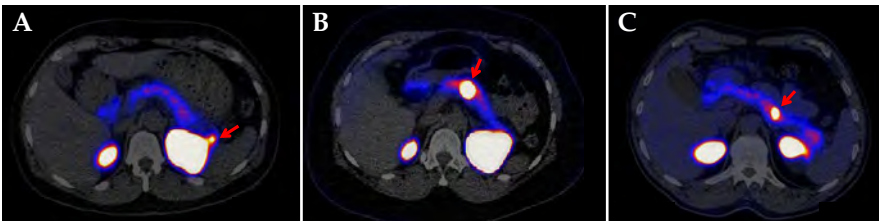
Transversal fused PET/CT images of the abdomen showing the detected insulinomas in patient 2 (A), patient 3 (B) and patient 4 (C). Lesions are indicated with red arrows.
